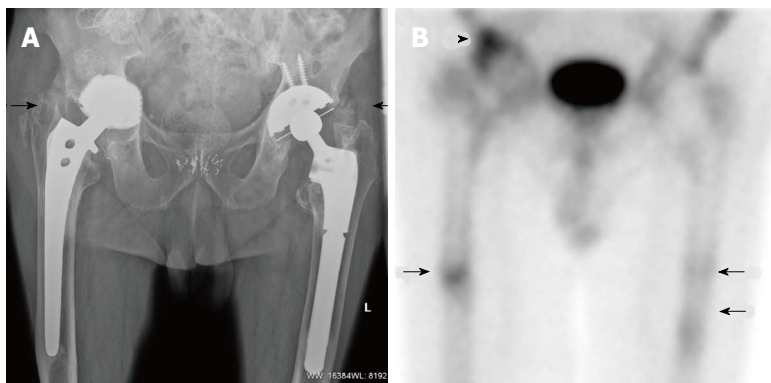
Aseptically loosened right hip arthroplasty. A: X-ray reveals medial protrusion of the acetabular component of a painful 15 year old hip replacement. There is heterotopic ossification around both greater trochanters (arrows); B: On the ^{99m}Tc-methylene diphosphonate bone scan, there is focally increased radiopharmaceutical accumulation at the distal tip of the femoral component (arrow) of the right hip replacement and lateral to the femoral neck (arrowhead) corresponding to the heterotopic bone seen on the X-ray. An aseptically loosened prosthesis was revised. Focally increased radiopharmaceutical accumulation is present at the tip of the femoral component of the asymptomatic left hip arthroplasty (double arrows) which also was 15 years old.
